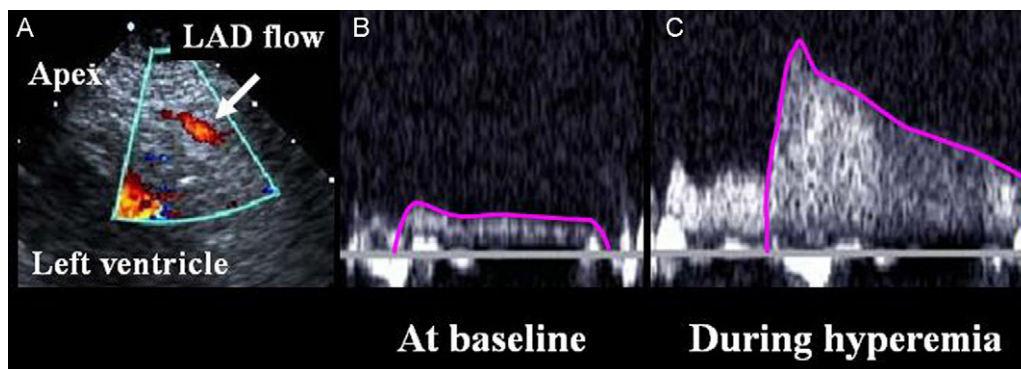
Transthoracic Doppler echocardiography images demonstrating the technique of measurement of coronary flow reserve in the left anterior descending (LAD) coronary artery. (A) Visualization of coronary blood flow in the distal LAD. (B) Measurement of basal mean diastolic flow velocity. (C) Measurement of hyperemic flow velocity.
